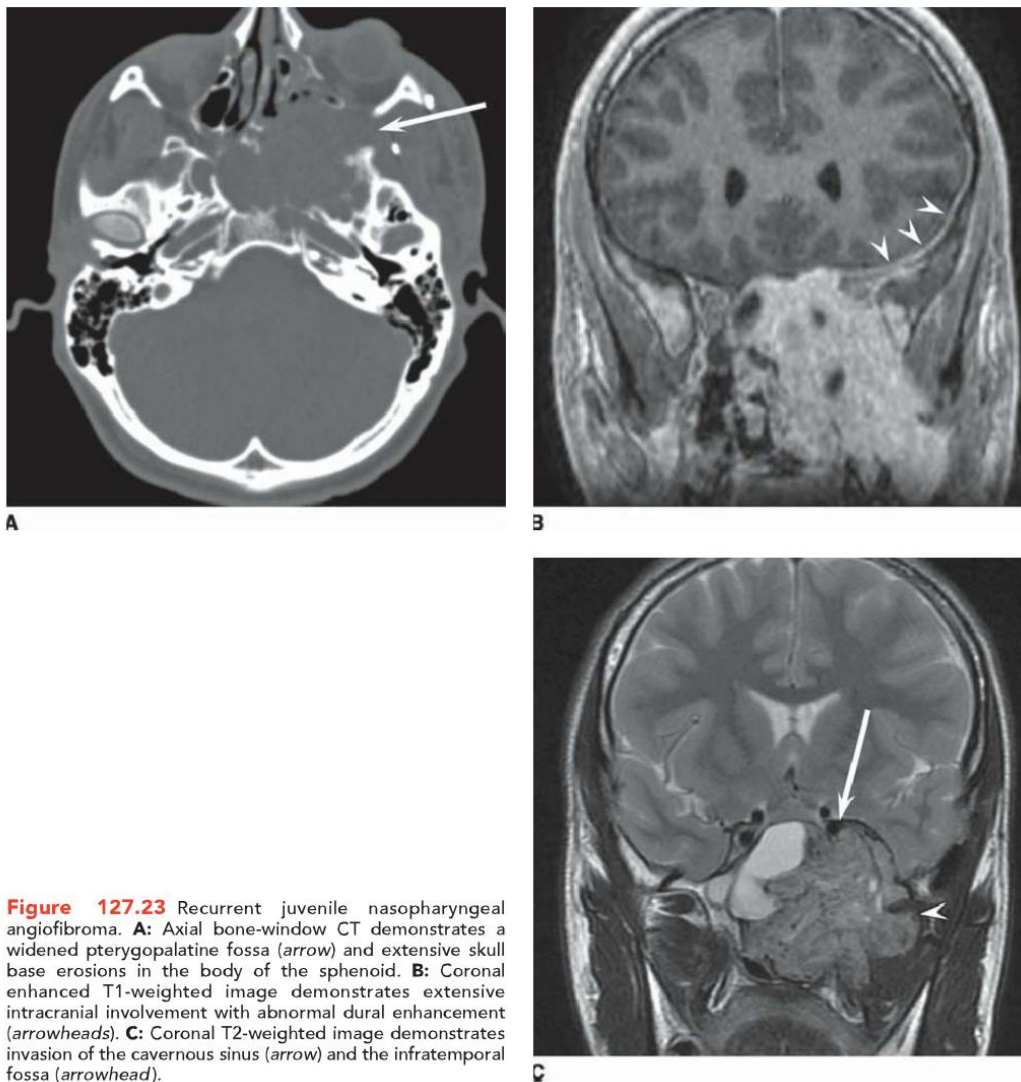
Recurrent juvenile nasopharyngeal angiofibroma. A: Axial bone-window CT demonstrates a widened pterygopalatine fossa (*arrow*) and extensive skull base erosions in the body of the sphenoid. B: Coronal enhanced T1-weighted image demonstrates extensive intracranial involvement with abnormal dural enhancement (*arrowheads*). C: Coronal T2-weighted image demonstrates invasion of the cavernous sinus (*arrow*) and the infratemporal fossa (*arrowhead*).
